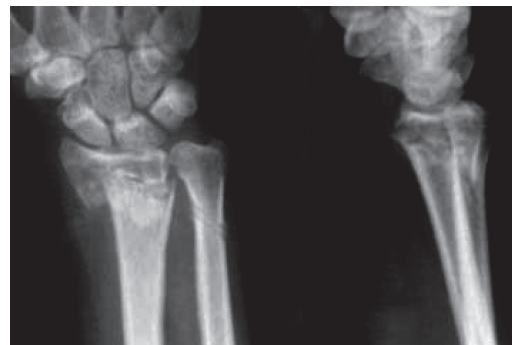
Radiographs on PA and lateral planes of a pseudoarthrosis of distal radius fracture in patient number 4.
